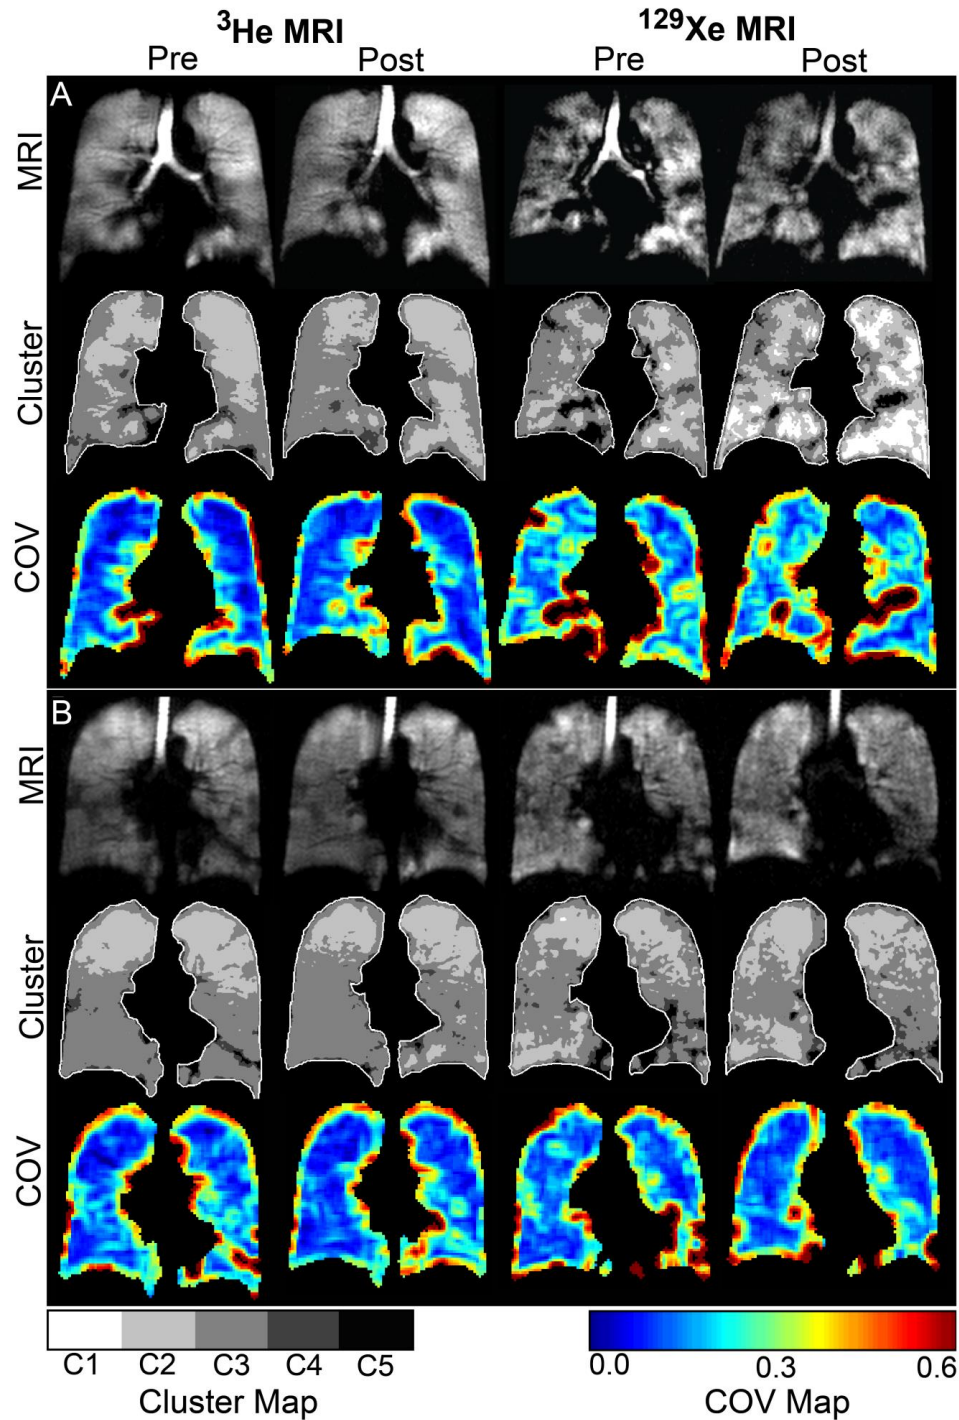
^3He and ^{129}Xe MRI pre- and post-salbutamol.
